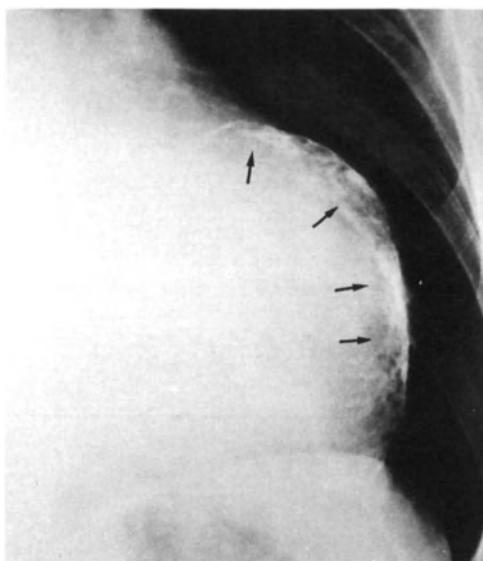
The chest radiograph shows a considerably enlarged heart with an apical bulge due to a large apical left ventricular aneurysm.
